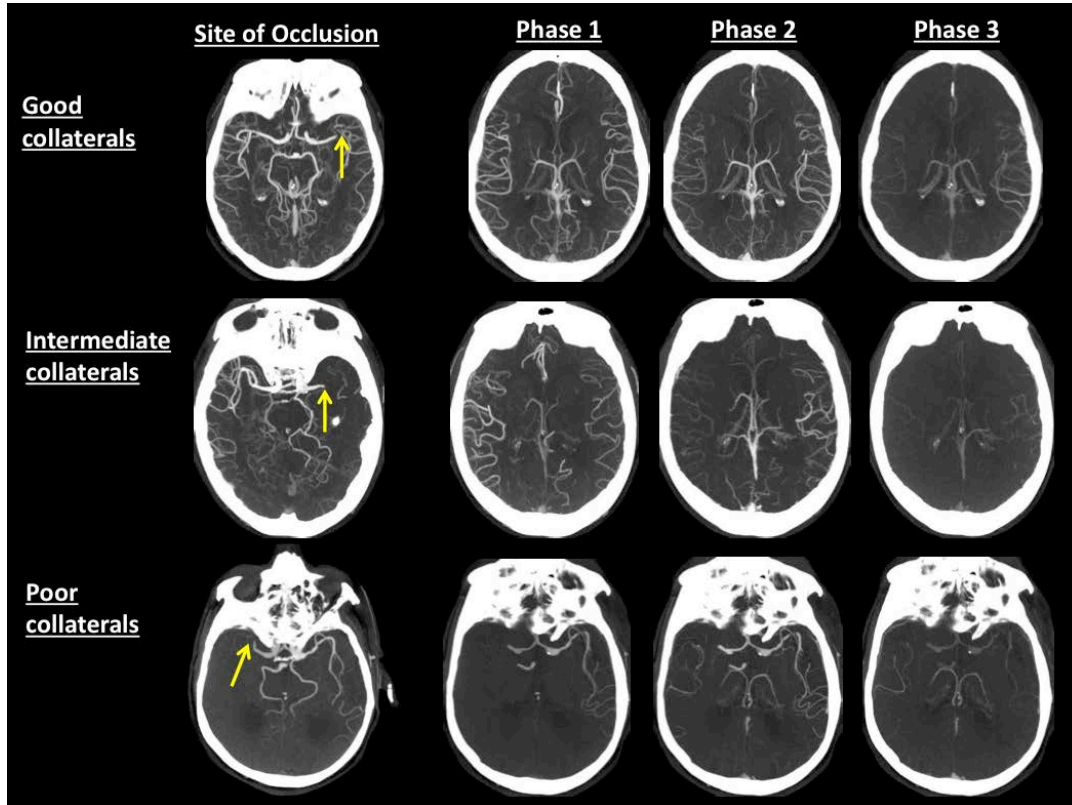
Upper panel shows a patient with a left M1 MCA occlusion (arrow) and good collaterals (backfilling arteries) on multi-phase CTA. Middle Panel shows a patient with a left M1 MCA occlusion (arrow) and intermediate collaterals. Lower panel shows a patient with a right M1 MCA occlusion (arrow) and poor collaterals (minimal backfilling arteries) on multi-phase CTA.
